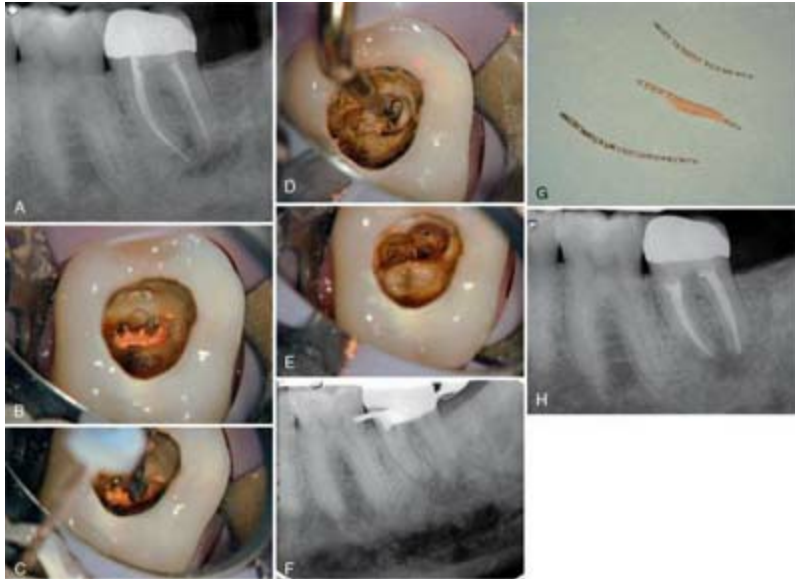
Metal carrier retreatment. A, Preoperative radiograph. B, Metal carriers exposed by careful excavation of gutta percha. C, Use of the Touch 'n Heat instrument to heat the carriers and soften the gutta-percha. This allowed removal of one of the carriers using modified Steiglitz forceps. The other could not be removed using heat or solvents. D, Ultrasonic troughing around the carrier to facilitate grasping it with forceps. E and F, Carriers removed and confirmed with a radiograph. G, Metal carriers showing gutta-percha still adhering to them. H, Final obturation of the tooth.
